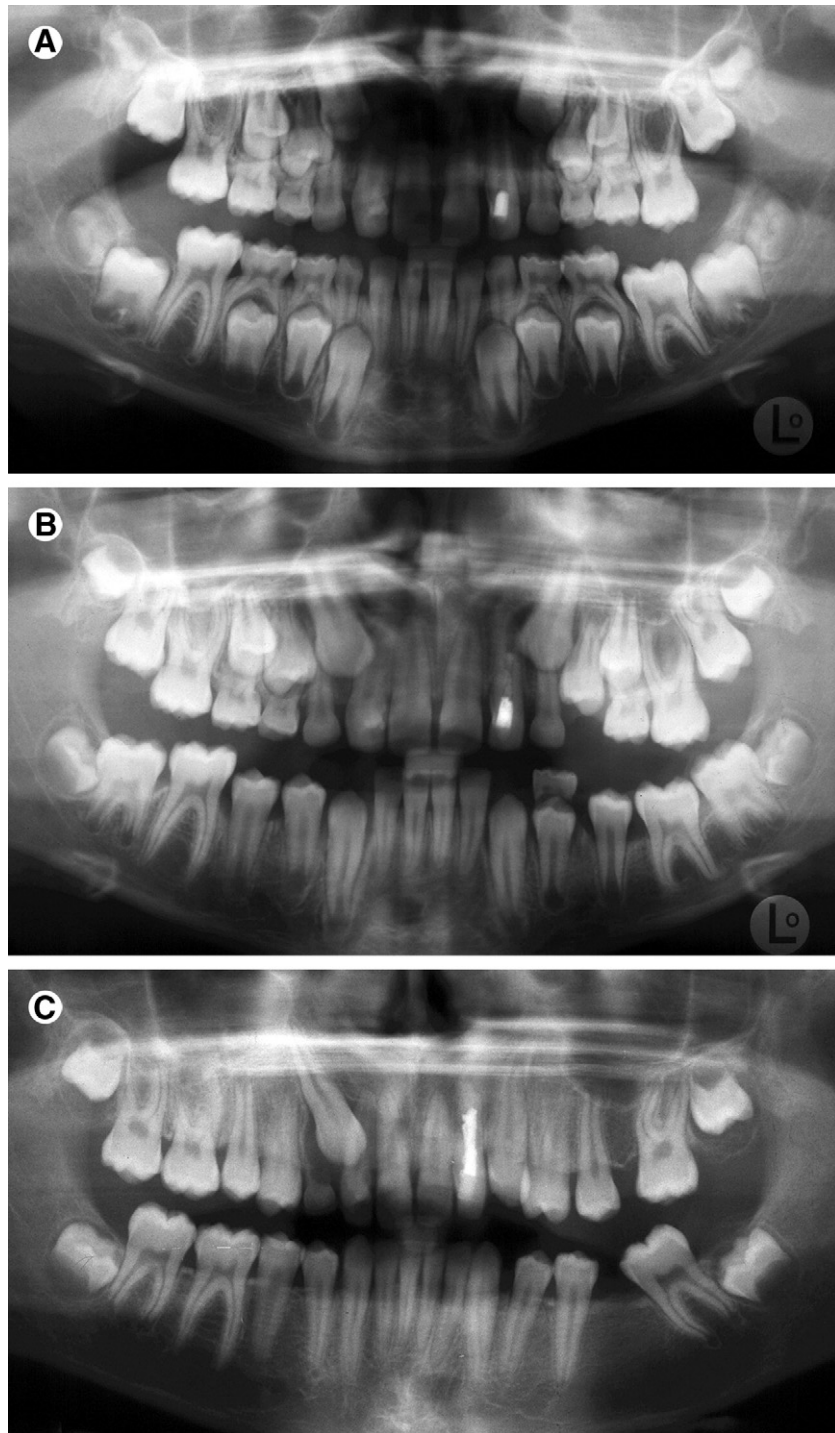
(A) Pretreatment panoramic radiograph; 9-year 10-month-old male. (B) Panoramic radiograph immediately before extraction of the left Mx and Md 1st molars; 10-year 11-month-old. (C) Panoramic radiograph demonstrates manifestation of the developing malocclusion on the left side: mesial tipping of the Md 2nd molar, distal drift of the Md premolars, and mesial drift of the Mx 2nd molar; 13-year 0-month-old.
